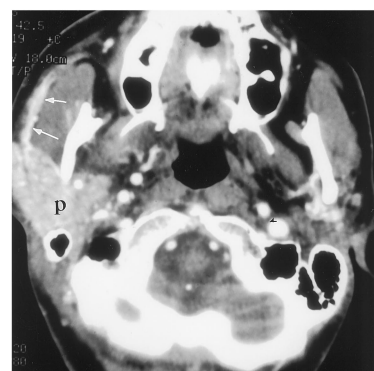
Acute viral parotitis. Axial contrast-enhanced CT image shows enlargement and intense enhancement of the right parotid gland (*p*) and accessory lobe (*arrows*). No obstructing calculus is present, and Stensen's duct and the intraglandular ducts are not dilated.
